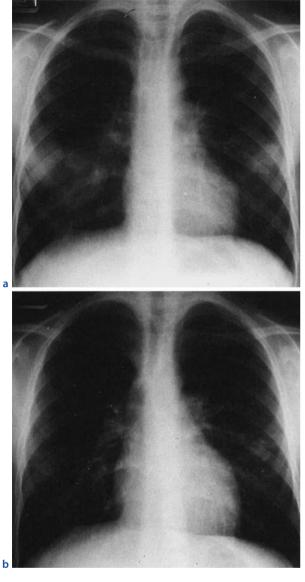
a Chest radiograph of an 8-year-old girl with ABA. b Note the improvement of the girl after 2 weeks of treatment with high dose oral corticosteroids
